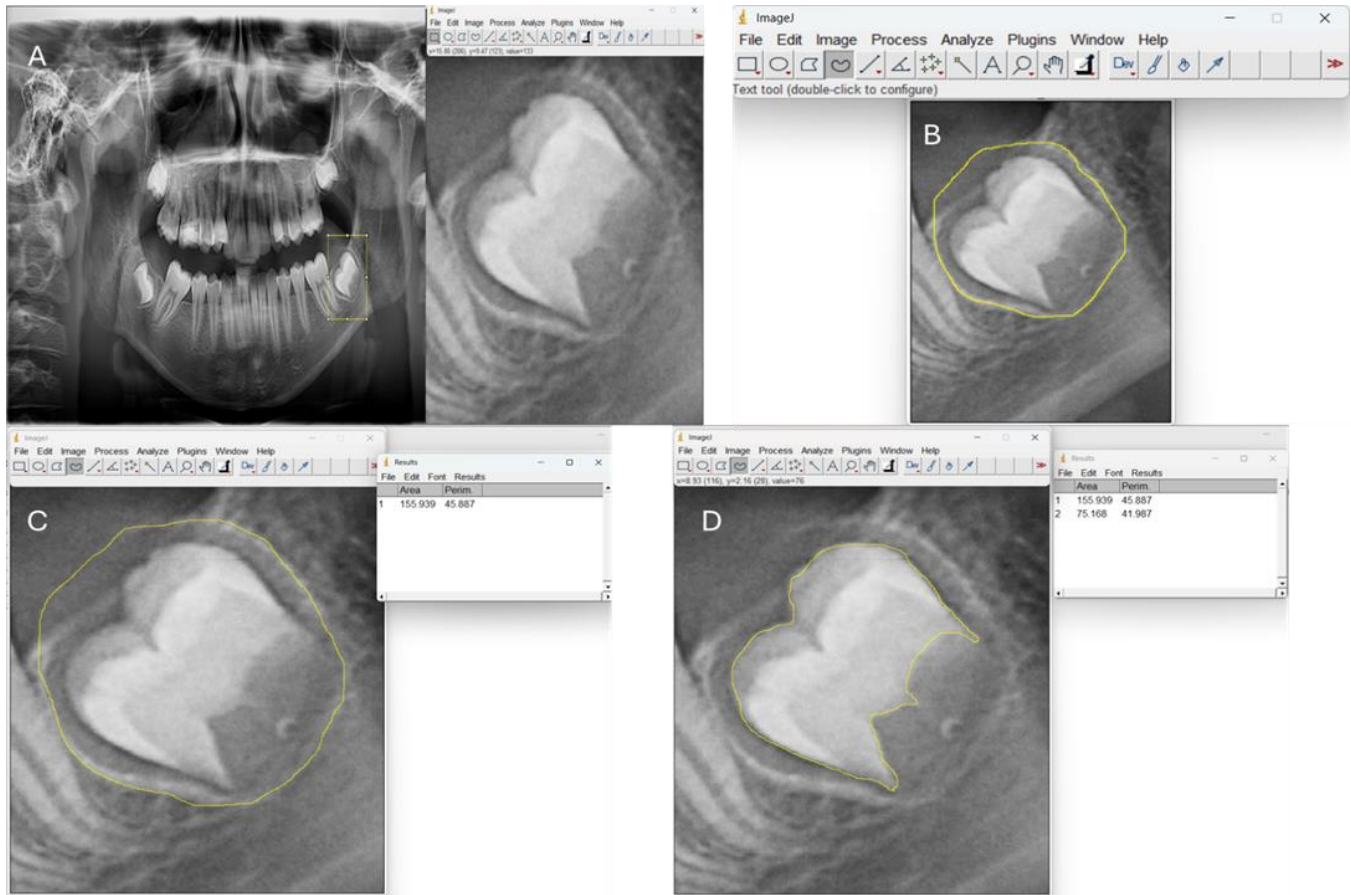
Using ImageJ tools to calculate the crypt and tooth areas of the mandibular second molar. (A) The developing tooth is identified within the radiographic image. (B) Tracing both the mineralized and follicular areas using the draw tool. (C) Area quantification of the traced region is performed through the Analyze-Measure function. (D) Tracing only the developing tooth using the draw tool, and the area is measured again using the same method.
